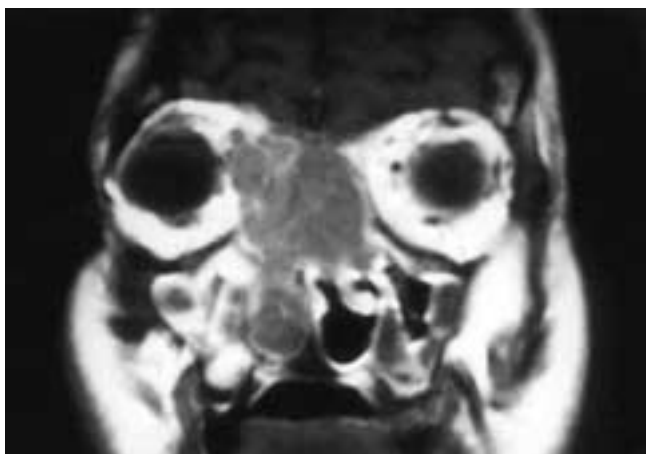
Coronal T1-weighted, contrast-enhanced MR image shows a nodular, destructive lesion in the nasal fossae and both ethmoid sinuses. The tumor has invaded the right orbit and skull base. Inflammatory disease is present in both antra. This patient had an adenocarcinoma.
